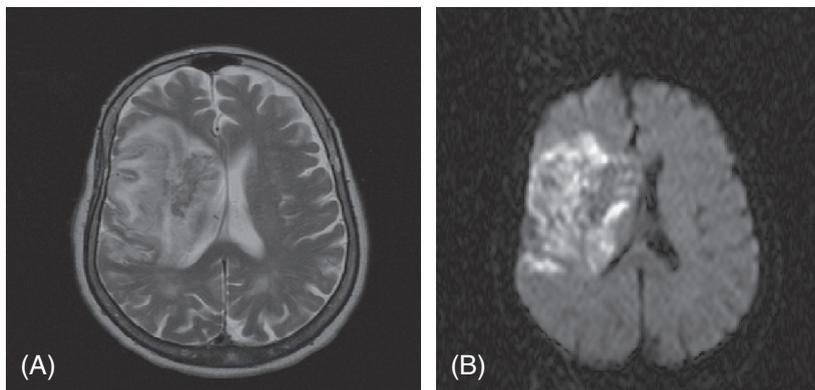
T2 (A) and diffusion-weighted (B) MRI sequences showing an infarct involving almost all the territory of the middle cerebral artery; part of the inferior (posterior) division is spared.
